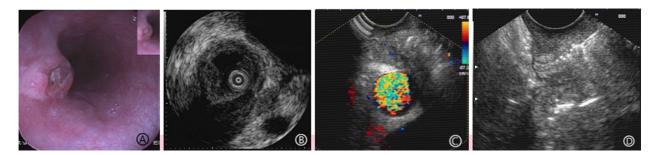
(A) Gastroscopy showed an extrinsic bulge protruding into the esophageal lumen with ulcerated mucosa. (B) Miniprobe EUS revealed full-thickness involvement of esophageal wall by a heterogeneous hypoechoic mass, with disruption of the adventitia. (C) Linear array EUS displayed enlarged heterogeneous hypoechoic mediastinal lymph node infiltrating the esophageal wall, with interior hyperechoic strands. (D) Linear array EUS-guided deep biopsy. The opened biopsy forceps was visualized endosonographically.
